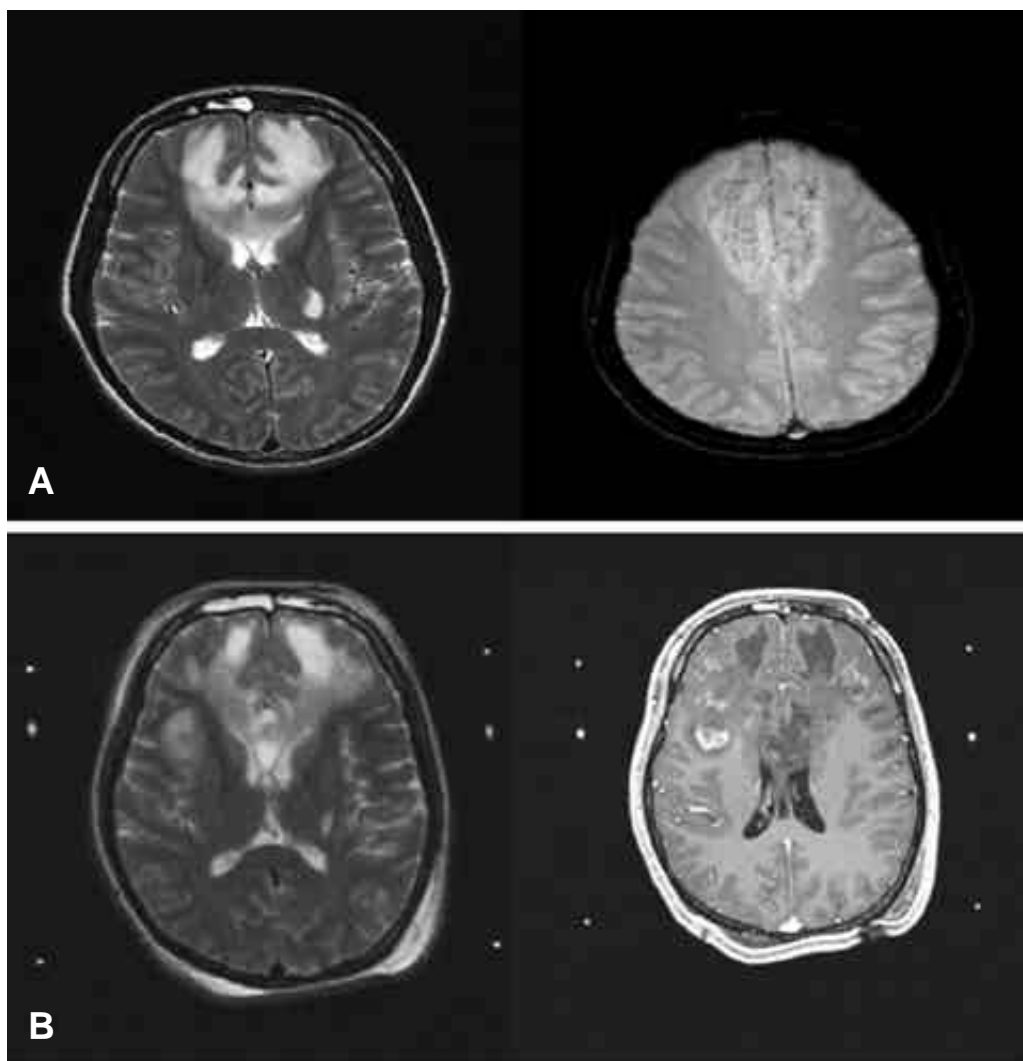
(A) One month after the first symptom, MRI revealed new lesions in bilateral frontal lobes with genu of corpus callosum and Gradient echo image disclosed multiple small dark signals suggesting of petechial hemorrhages in these lesions. (B) At the time of symptom aggravation though extensive steroid therapy, MRI showed increased extent of bilateral frontal lesions with necrosis and newly developed multiple irregular enhancing lesions.
